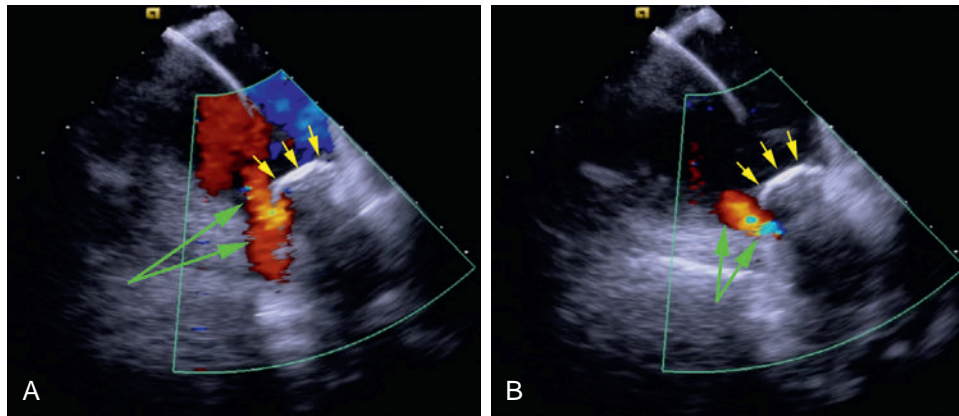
Intracardiac Echocardiography to Assess Pulmonary Vein (PV) Occlusion by the Cryoballoon. The cryoballoon (yellow arrows) is positioned at the antrum of the left superior PV. (A) Color Doppler reveals flow (green arrows) at the inferior aspect of the balloon consistent with flow from the nearby left inferior PV. (B) Color Doppler reveals flow (green arrows) at the inferior aspect of the balloon consistent with leak from the left superior PV itself, indicating incomplete PV occlusion.
